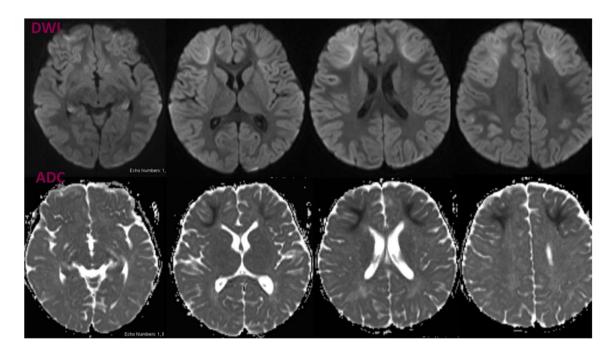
Magnetic resonance imaging (MRI) brain with diffusion-weighted imaging (DWI) sequences on the top and apparent diffusion coefficient (ADC) map on the bottom. Images show bilateral frontal subcortical restricted diffusion mainly involving the middle frontalgyri with 'Bright tree' appearance suggestive of cytotoxic oedema of acute encephalopathy with biphasic seizures and late diffusion restriction.
